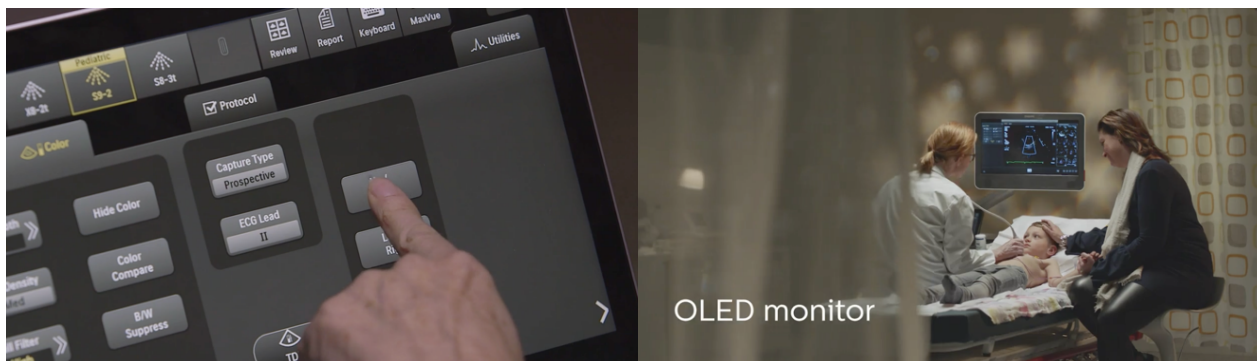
Philips EPIQ (Source: <https://www.philips.nl/healthcare/solutions/ultrasound/cardiovascular-ultrasound>)
